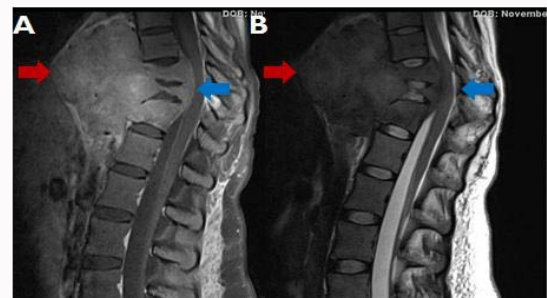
The sagittal enhanced T1-weighted images A and the coronal T2-weighted images B. showed the large infiltrate posterior mediastinal mass causing destruction of vertebral bodies of T9, T10, and T11 with epidural component measures surround the spinal cord, this results in significant spinal canal stenosis resulting in cord compression with evidence of signal alteration. No other lesion in the spinal canal is noted.
